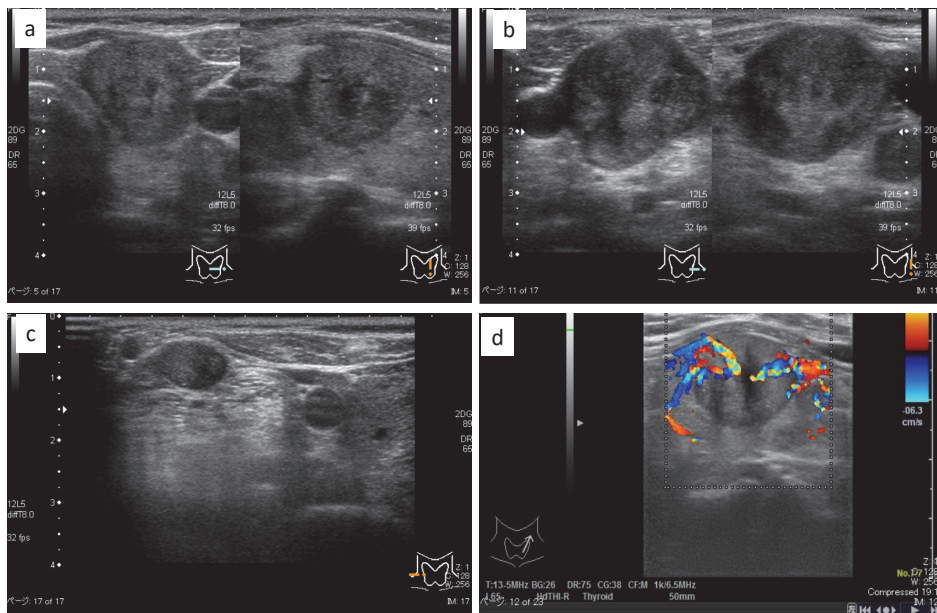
Ultrasonographic findings: Lt. lobe mass (a). Lt. cervical lymph node (b). Rt. cervical lymph node (c). Color Doppler (d).
